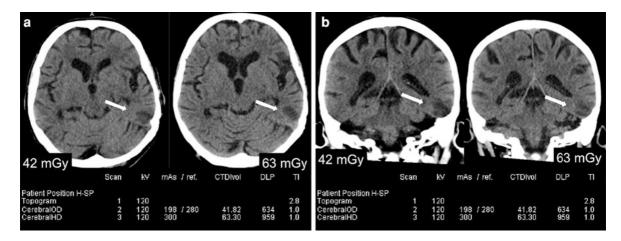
Brain CT performed in two consecutive acquisitions obtained at 120 kV (64×0.6 mm) in a 70-year-old man with acute stroke. *Arrows* show a hypoattenuated area in the left parieto-temporal region. a shows side-by-side comparison of representative axial slices with 3 mm thickness. The *left one* is acquired at CTDIvol of 42 mGy with tube current modulation switched on. The reference image quality index is at 280 mAs. The mean delivered effective tube current time product is at 198 mAs. The second acquisition displayed at the *right side* is obtained without tube current modulation with an effective tube
